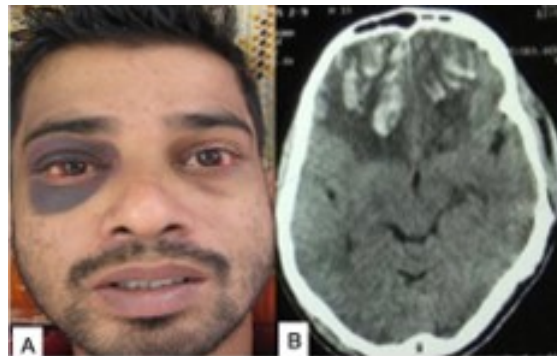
(A) Patient with black eye due to front-basal fracture. (B) CT findings showing a bifrontal basal hemorrhagic contusion caused by a road traffic injury. Source: Figure by authors, used with patient's consent.
